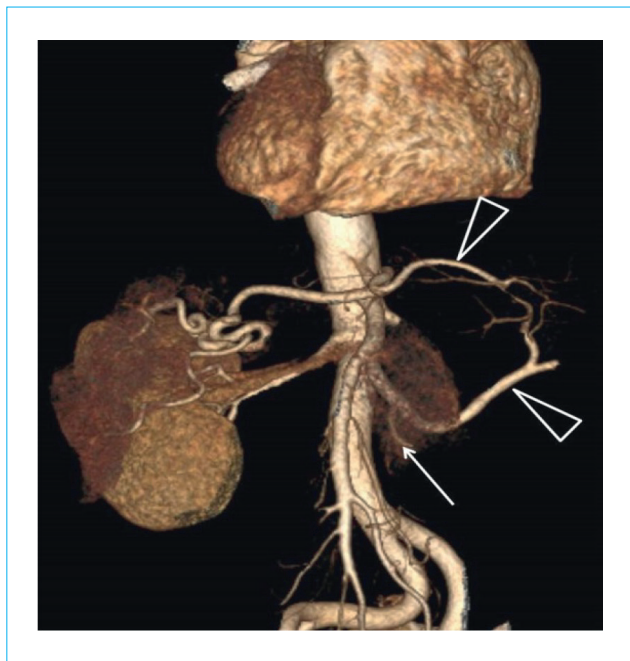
Computed tomography of abdominal organs with intravenous contrast, volumetric imaging (VR-reconstruction). Two hepatic arteries (triangular arrows): the right one departs from the superior mesenteric artery, the left one — from the abdominal trunk. The gastroduodenal artery departs from the right hepatic artery (arrow)
